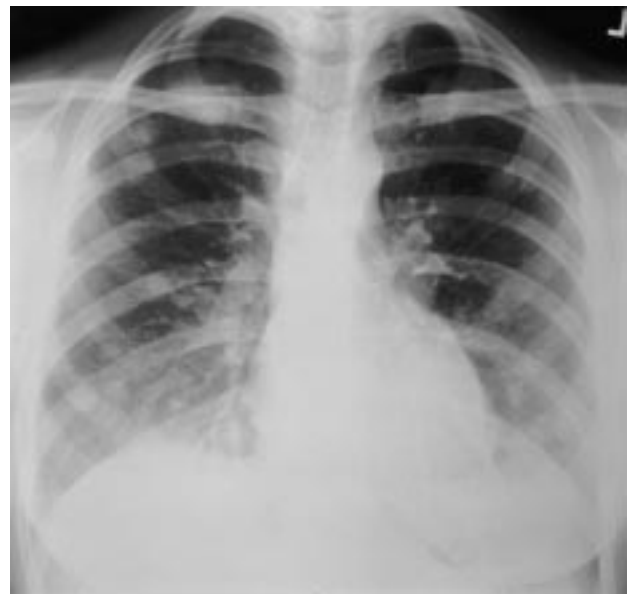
Chest radiograph frontal view, at admission showing multiple ill-defined opacities.
